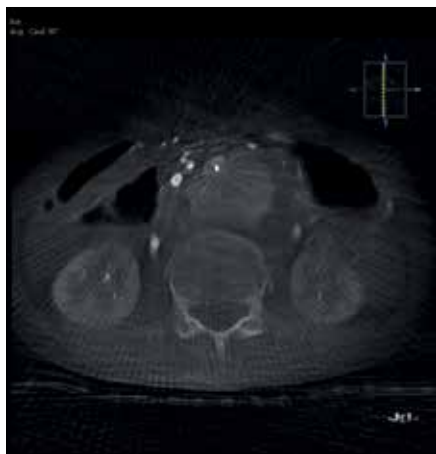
Cone-beam CT aortogram in axial plane, better demonstrates the extent of the pseudoaneurysm arising from the infrarenal abdominal aorta.
